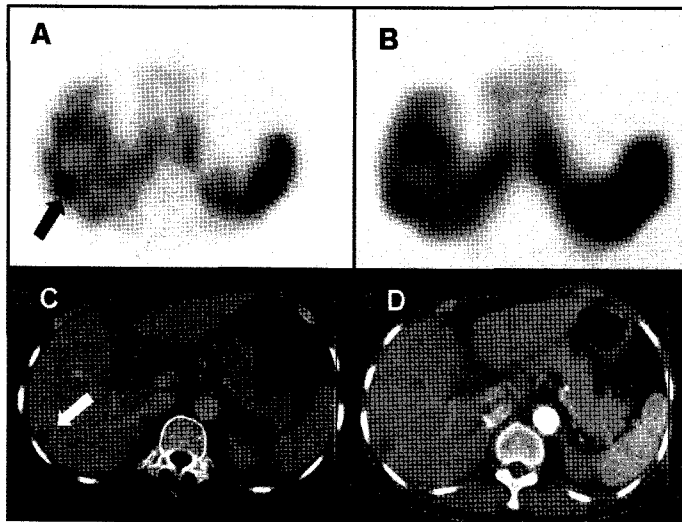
OSEM image (A) shows higher contrast than that of FBP and better estimation of real size of the lesion considering the CT findings (C, D).
